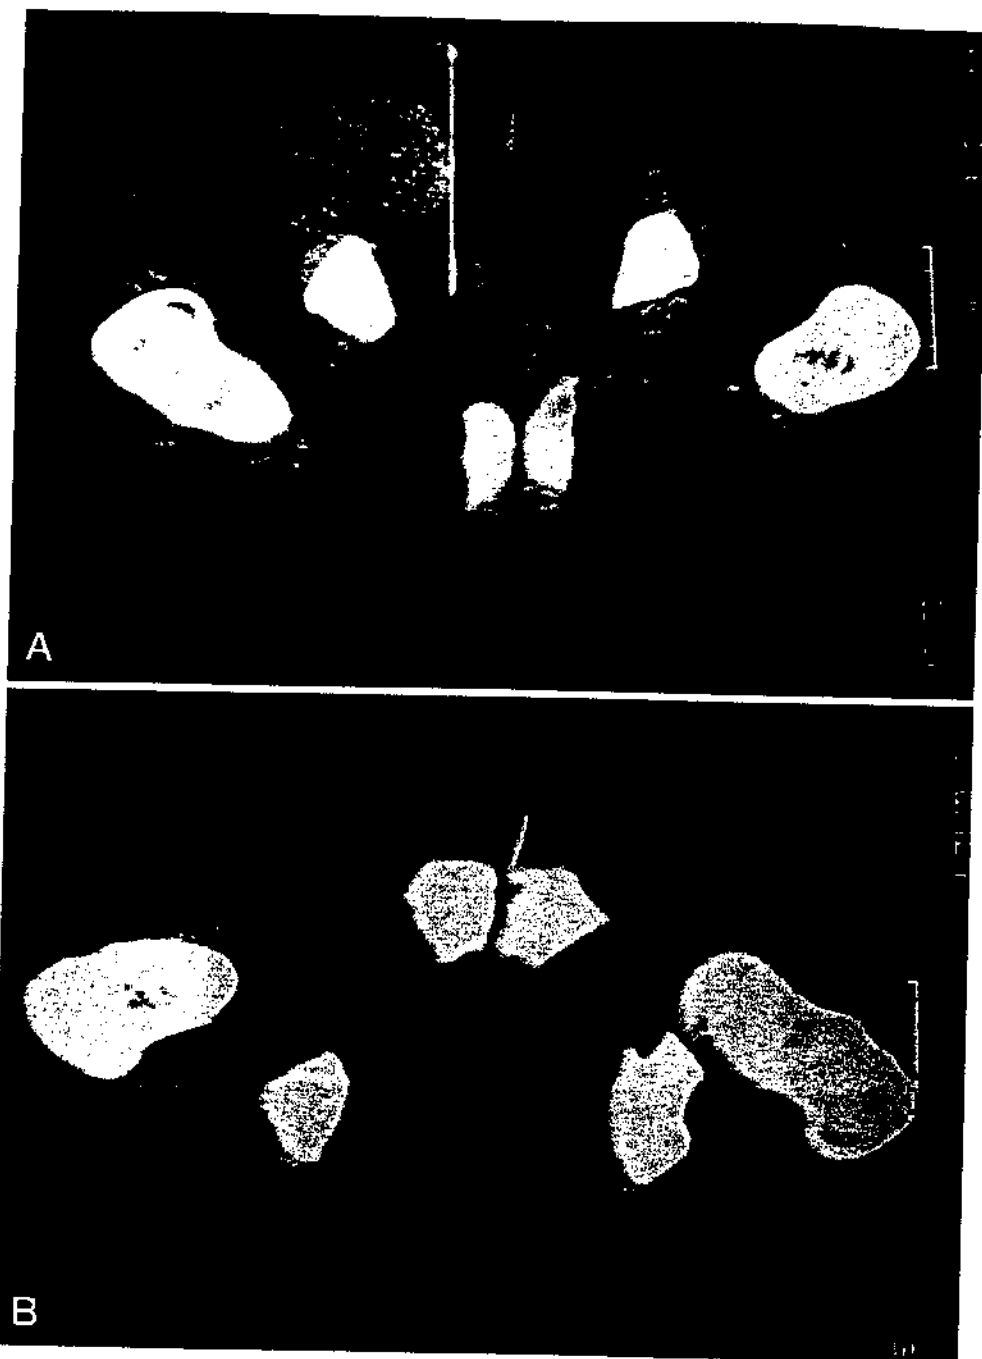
A) CT-directed aspiration of left obturator internus via posterior approach. B) Anterior aspiration of pubis.
